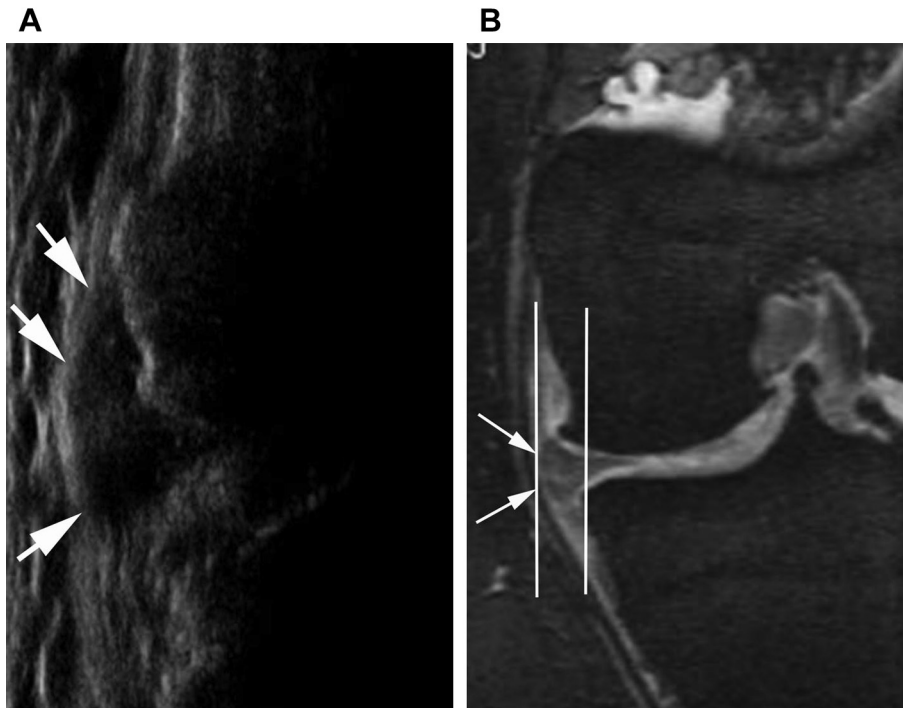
Imaging assessment of meniscal extrusion. A. Ultrasound screenshot shows moderate medial meniscal extrusion (arrows). Note sound extinction beyond the cortical bone and inability to assess the bone marrow (right side of image). B. Coronal DESS MR image shows medial meniscal extrusion (arrows and vertical lines) in the same patient. The tomographic viewing perspective of the MRI allows for assessment of all joint tissues in a given imaging plane.
